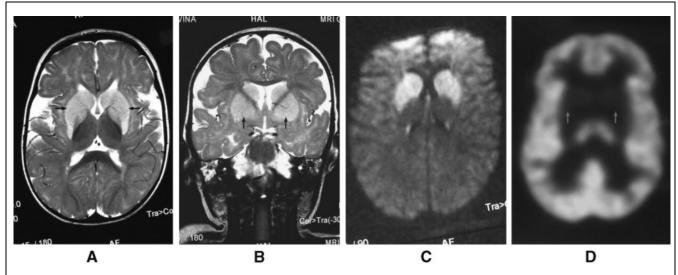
Acute striatal necrosis. Injury to the striatum in GA1 is typically acute and stroke-like. A 1-year-old Amish infant developed abrupt onset of behavioral arrest and lost postural control in the setting of fever, dehydration, *E. Coli* urinary tract infection, and bronchiolitis. A (axial) and B (coronal): Cranial MRI within 24 hr of the onset of the neurological syndrome shows focal symmetric tissue swelling and T2 hyperintensity that is continuous throughout the basal ganglia (arrows). C: The smaller diffusion-weighted signal is restricted to the infarcted area. D: FDG PET imaging on hospital day 6 shows striatal FDG uptake reduced to about 50% of the expected value (red arrows). Over the ensuing weeks, the patient developed severe dystonia as the putamina were replaced by slit-like gliosis. At 20 months of age, she was unable to speak, eat, sit, or use her hands.
